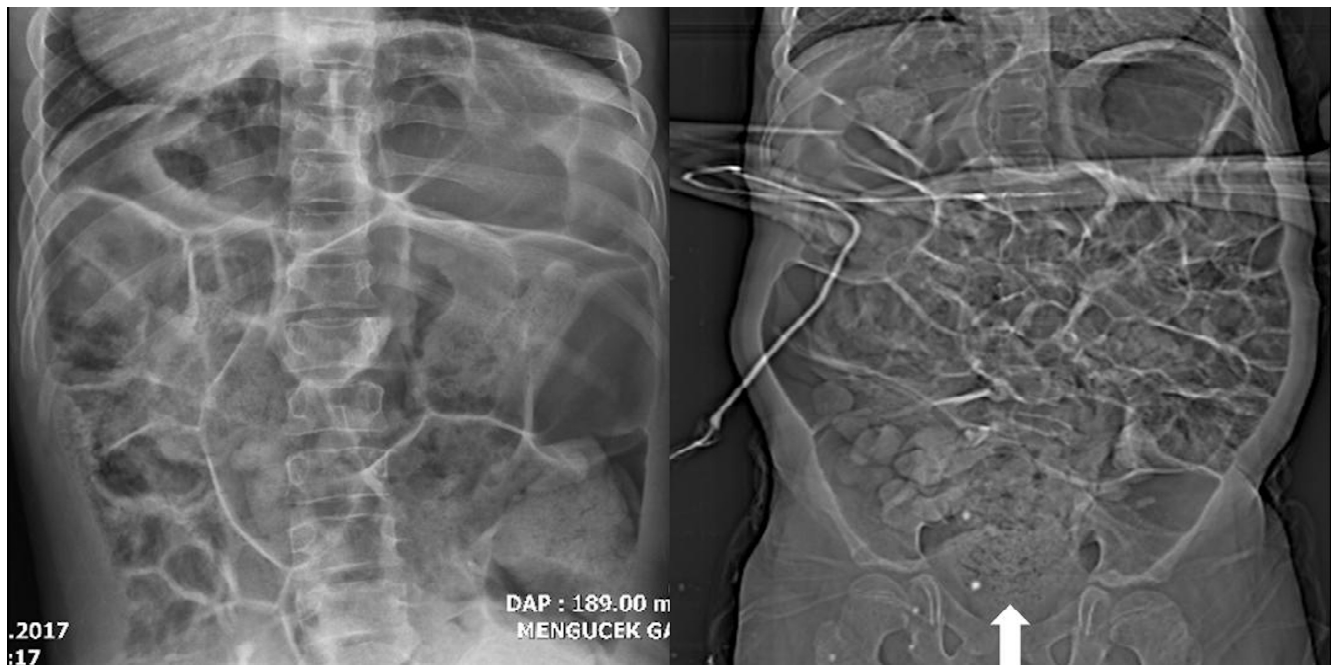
A plain X-ray studies of the abdomen revealed the dilatation of intestines and faecal impaction (arrow).
